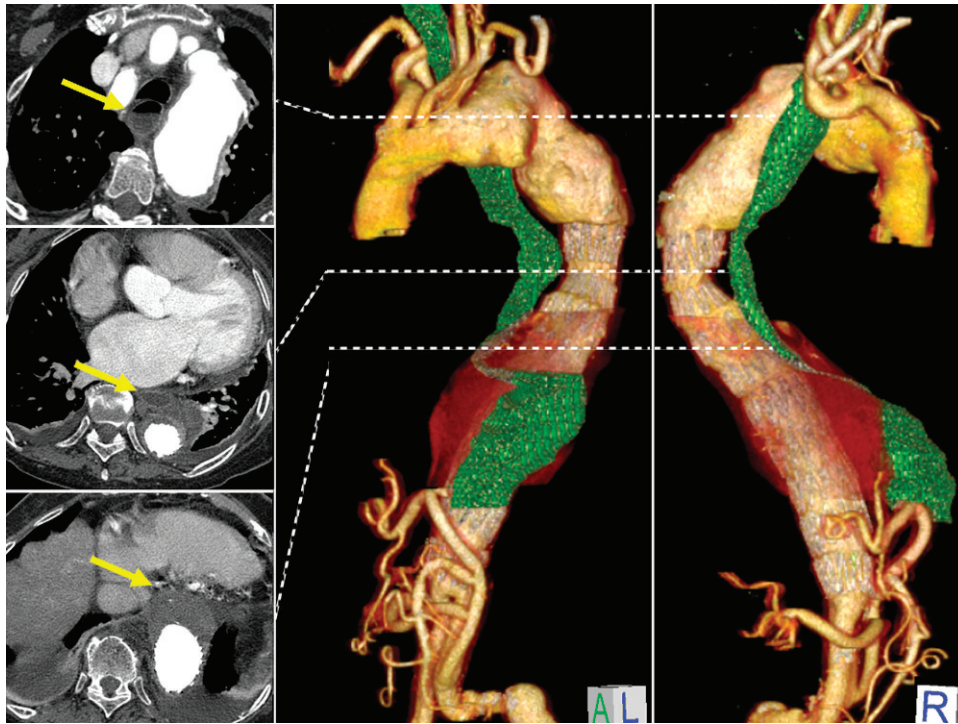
♦ Preoperative CT scan showing a type III thoracoabdominal aortic aneurysm that anteriorly displaces the esophagus at its distal third (arrows). Also of note is the marked thoracic kyphosis.
